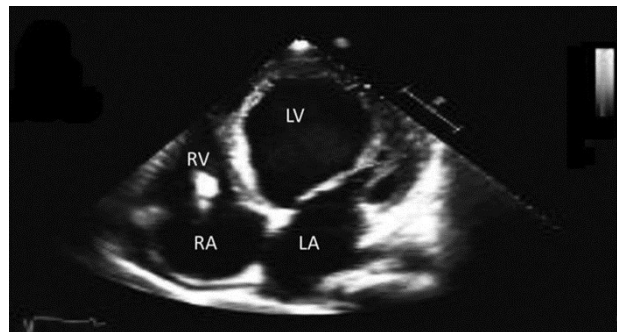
Echocardiography HCM, apical view
